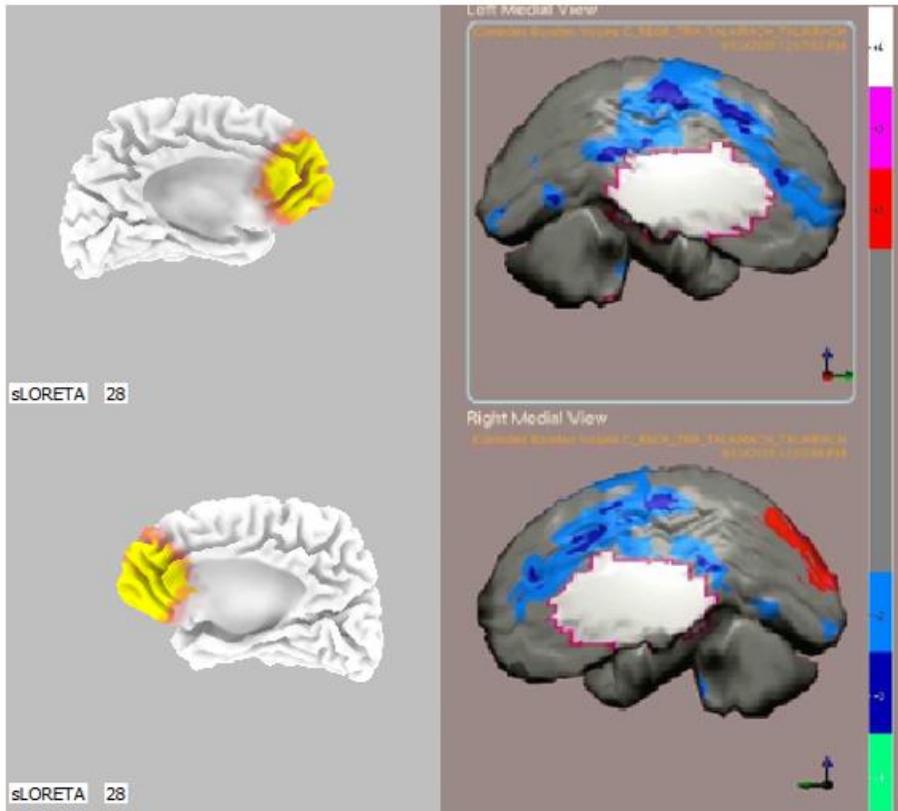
The 12.03Hz bilateral anterior cingulate source localization reiterating approximately the anterior half of this individual’s SPECT which also includes the posterior cingulate. Significant areas are confined to the medial portion of the hemisphere.
